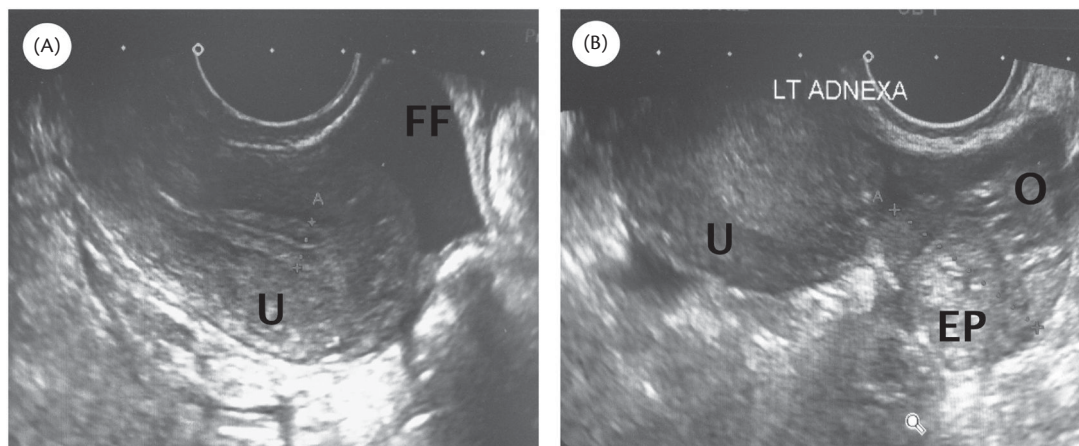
Ultrasonography of a tubal ectopic pregnancy. (A) Uterus (U) with a normal endometrial echo (measurement A) with free fluid (FF). (B) In the left adnexa next to the uterus (U) and medial to the ovary (O) is the adnexal mass (measurement A) representing the ectopic pregnancy (EP).
